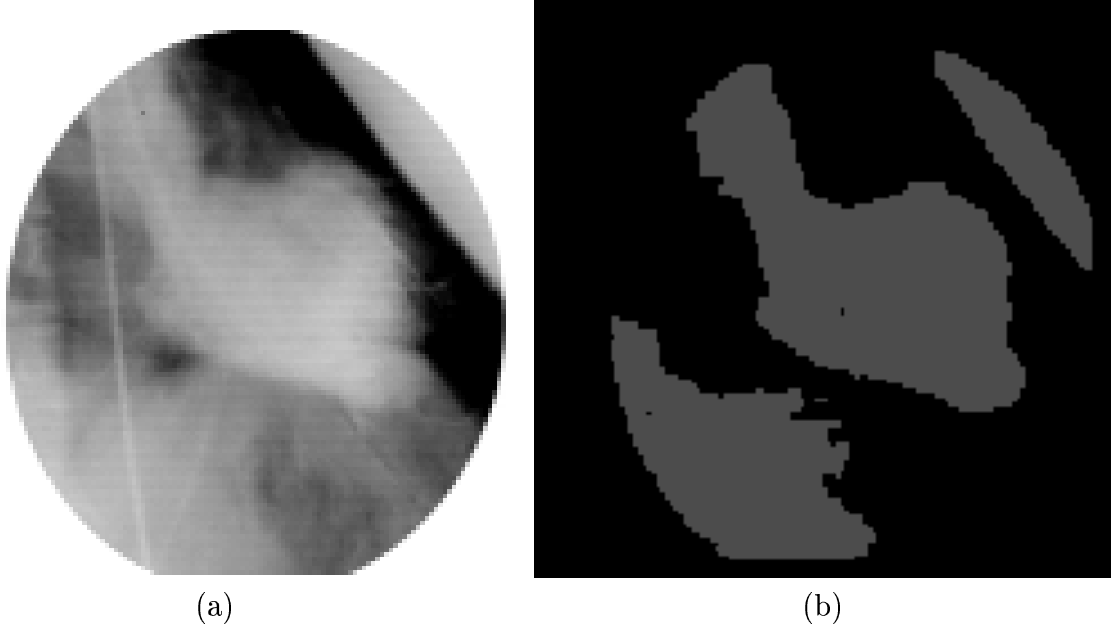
Contrastographic X-ray image of the left ventricle of the heart filled with iodine dye (a), the connected components in the “foreground” layer of the segmentation network (b) and the boundary of left ventricle and aorta (c).
